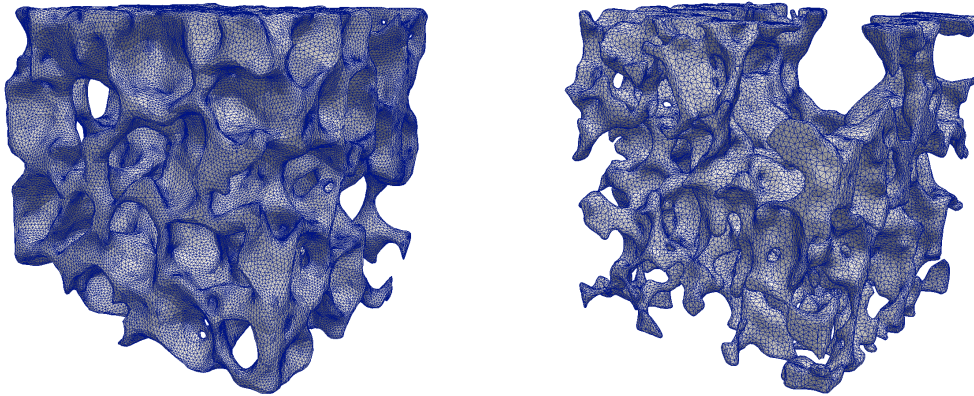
Reconstructed cubical-shaped volume meshes of synchrotron-based X-ray tomography scans of the alveolar microstructure. The left sample is taken from a region of homogenous tissue, whereas the right sample exhibits an inhomogeneity due to the crossing of a small airway at the top surface. Taken from [284] with permission.
